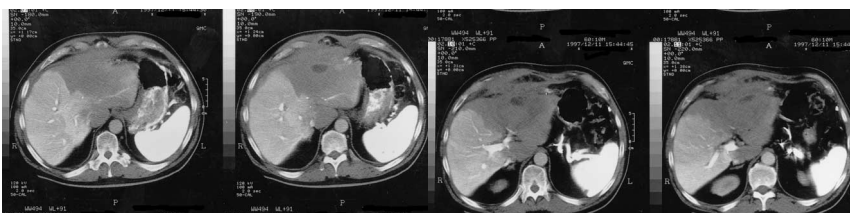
Computed tomography aorto-portogram. This demonstrates a solitary large mass involving the left lobe of the liver extending to the anterior abdominal wall and involving the transverse colon.
